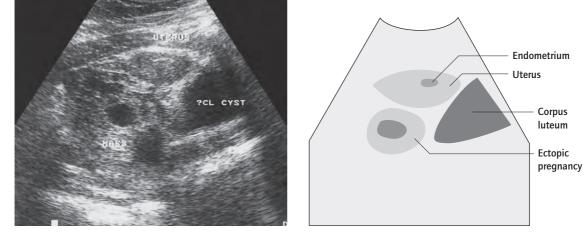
Ultrasound of ectopic pregnancy. It is unusual to visualize the ectopic pregnancy with ultrasound.
